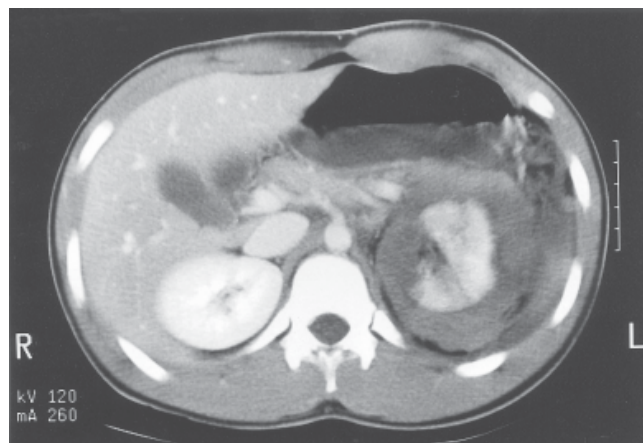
Abdominal CT scan showing grade IV renal rupture secondary to blunt abdominal trauma from a cricket bat handle.
